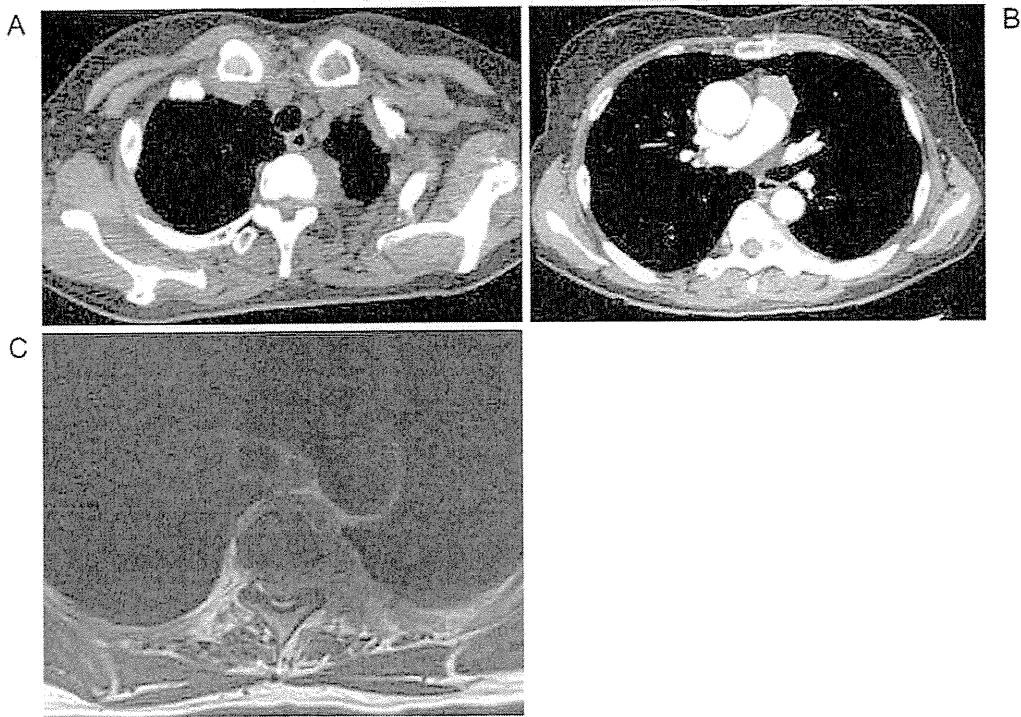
Chest computed tomography demonstrated a left posterior mediastinal mass expanding along the pleura (A) and an anterior mass (B). The left posterior mediastinal mass involved the thoracic vertebrae on chest magnetic resonance imaging (MRI) (C).
